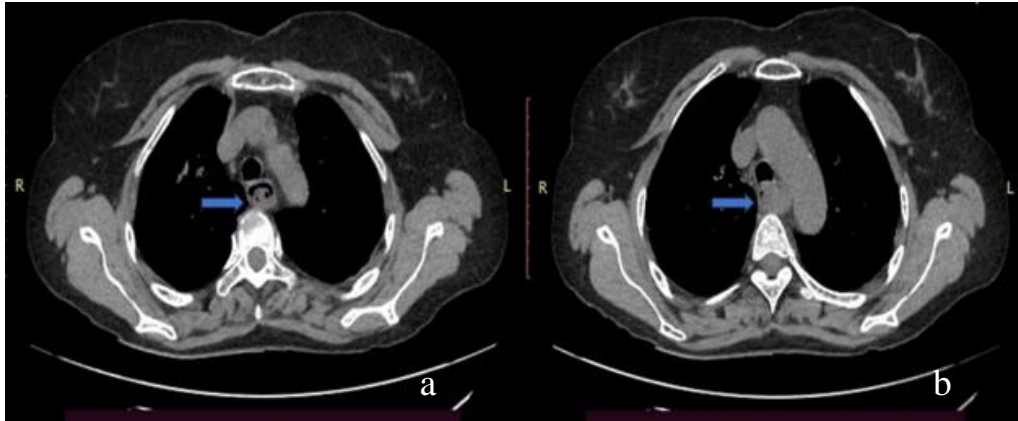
a, b.) CT thorax shows a well-defined, homogeneously enhancing oval lesion on the posterior oesophageal wall, measuring 4.7 × 2.4 × 1.4 cm (blue arrow).
